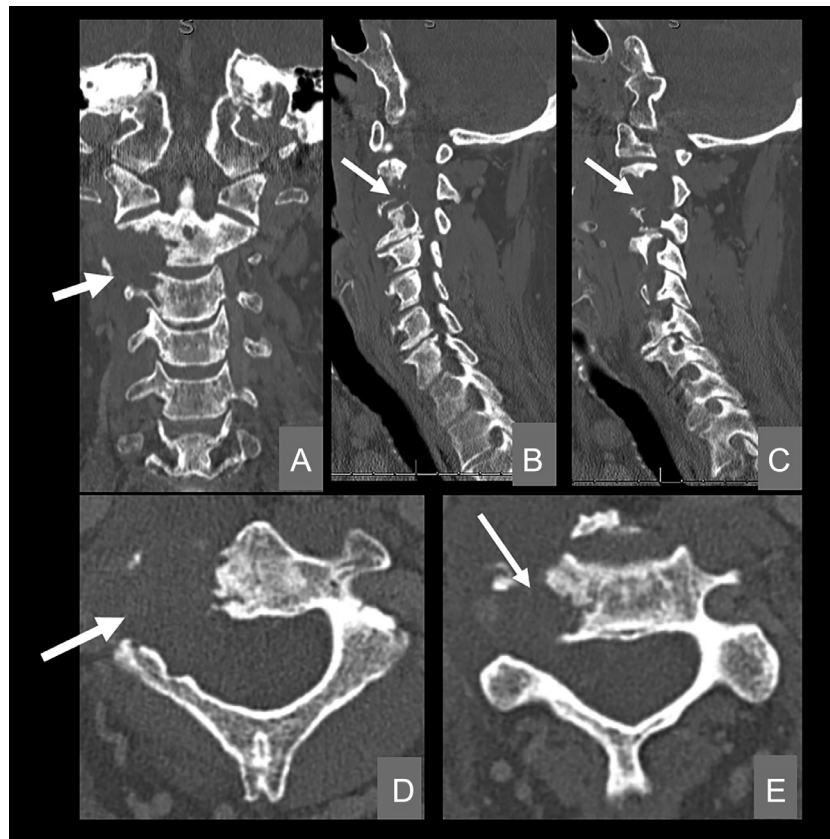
Preoperative coronal (A), sagittal (B and C), and axial (D and E) CT scan images showing the lytic bone lesion (white arrows) involving the bodies of C2 and C3, as well as the right C2 and C3 transverse foramina, which are widened.
